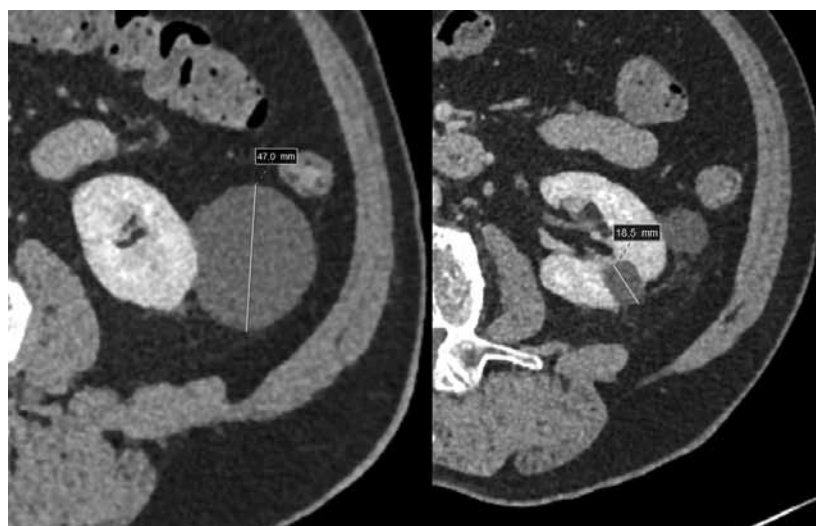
Contrast-enhanced CT images showing multiple cysts of the left kidney
